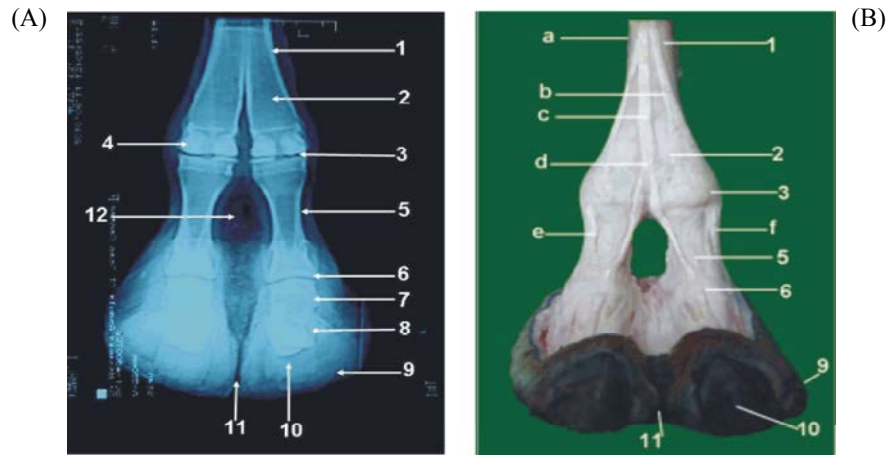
(A) Dorsoplantar CT image and (B) Dorsal view of dissected foot. 1, metacarpal bone ;2, divided metacarpal bone; 3, fetlock joint; 4, proximal sesamoid bones; 5, proximal phalanx; 6, pastern joint; 7, middle phalanx; 8, distal phalanx; 9, sole; 10,nail or pes; 11, interdigital notch; 12, interdigital septum; a, tendon of muscle extensor digitorum lateralis; b and c , medial and lateral tendons of muscle extensor communis; d, true common extensor tendon ; e, proper extensor tendon of the third digit ; f, proper extensor tendon of the fourth digit.
